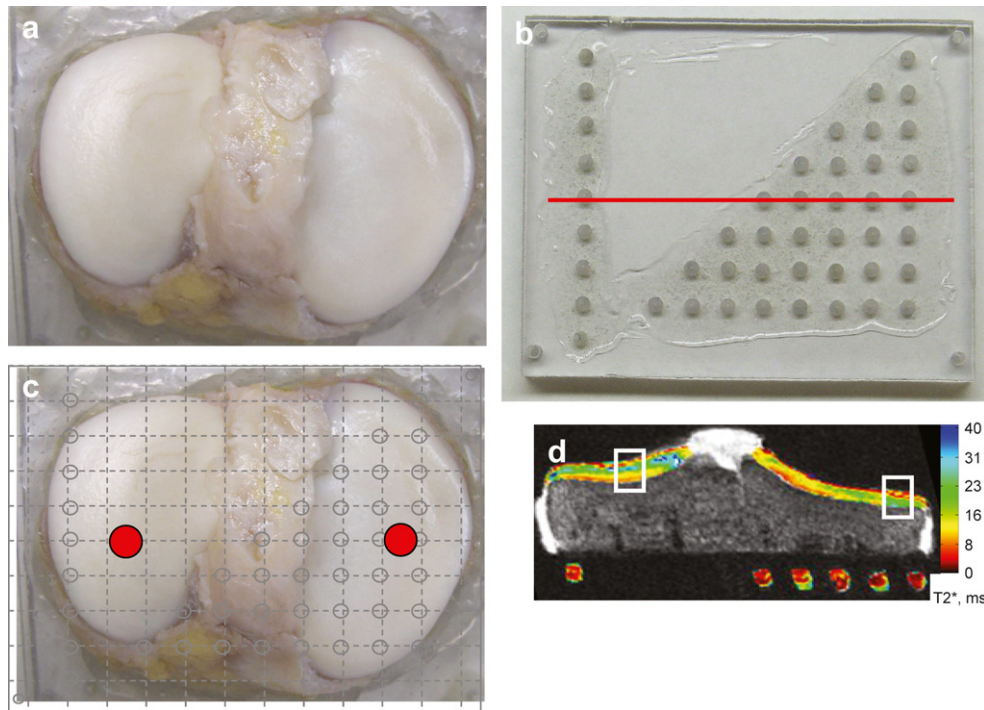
Spatial registration of MRI and PLM measurements was achieved by (a) mounting the human tibial plateau explants to acrylic adapter plates, and fixing the adapter plates to a 'registration' plate (b) embedded with precisely located MRI lucent markers. Osteochondral core locations (c, red circles) and MRI ROIs (d, white boxes) were spatially matched using the pattern of MRI lucent markers as a common reference frame (b, c, grey circles; d, multi-colored circles). The red line (b) indicates the plane of the example UTE- T_2^* map (d).
